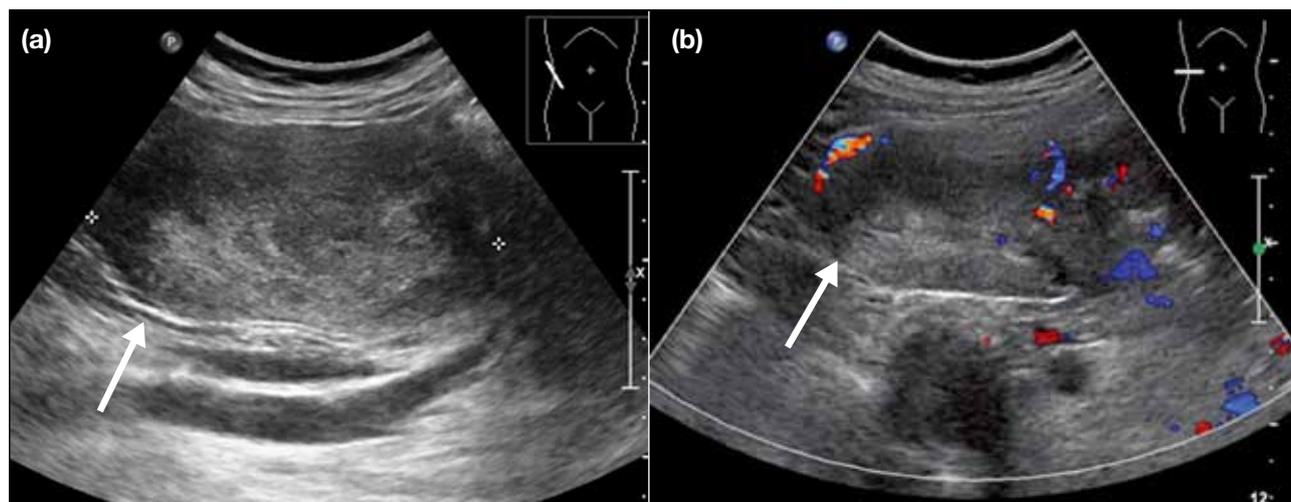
Ultrasound images show (a) a large well-defined echogenic mass in right lower abdomen closely abutting the kidney (arrow). No internal fat or calcification was identified; (b) internal vascularity was noted (arrow).
